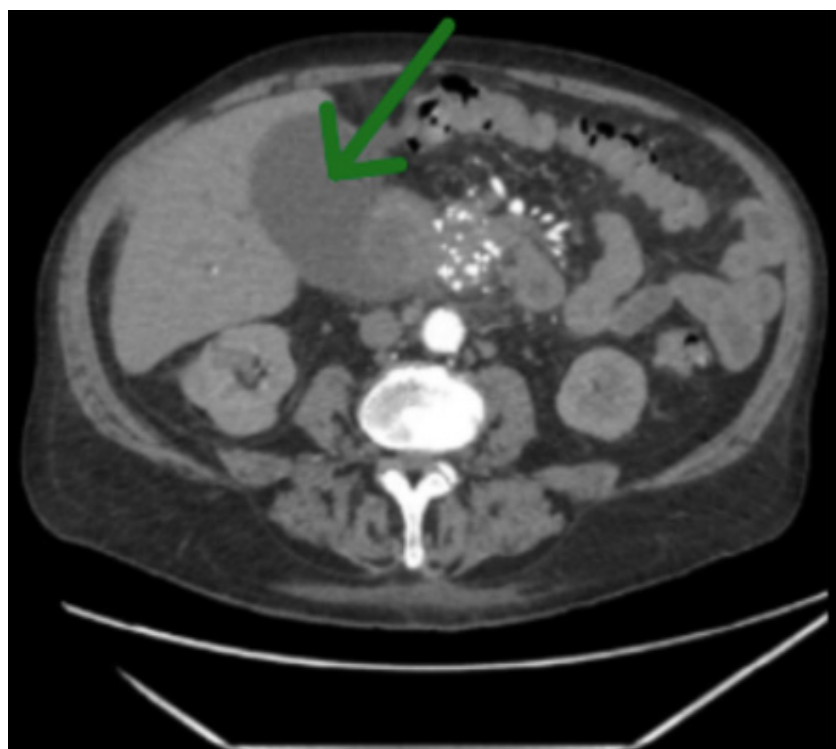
Abdominal CT: pancreatic calcifications and enlarged gallbladder
